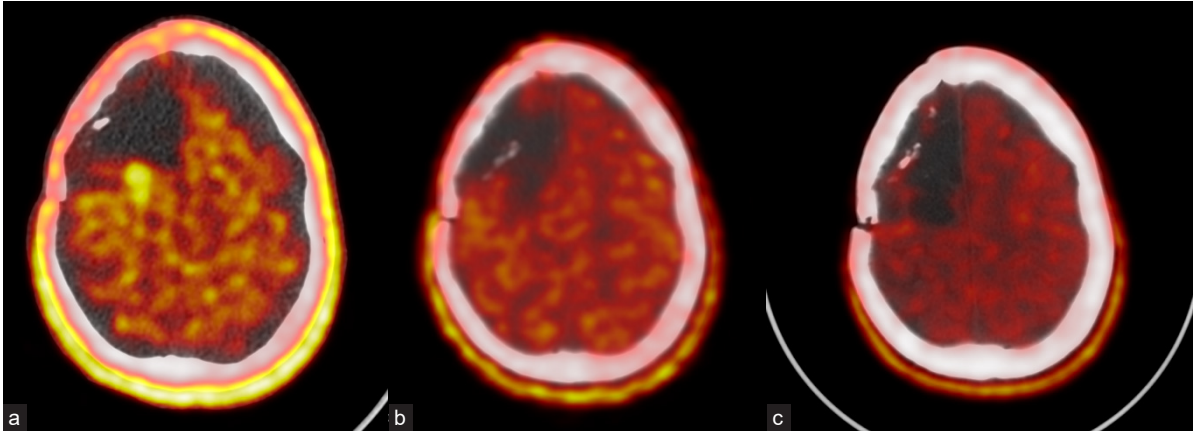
PET/CT with [11C] methionine (a) on the posterior border of the postoperative cyst a zone of increased accumulation = 2.4, size $13 \times 24 \times 17$ mm; (b) 1 month after PDT; and (c) 9 months after PDT – no recurrence.
